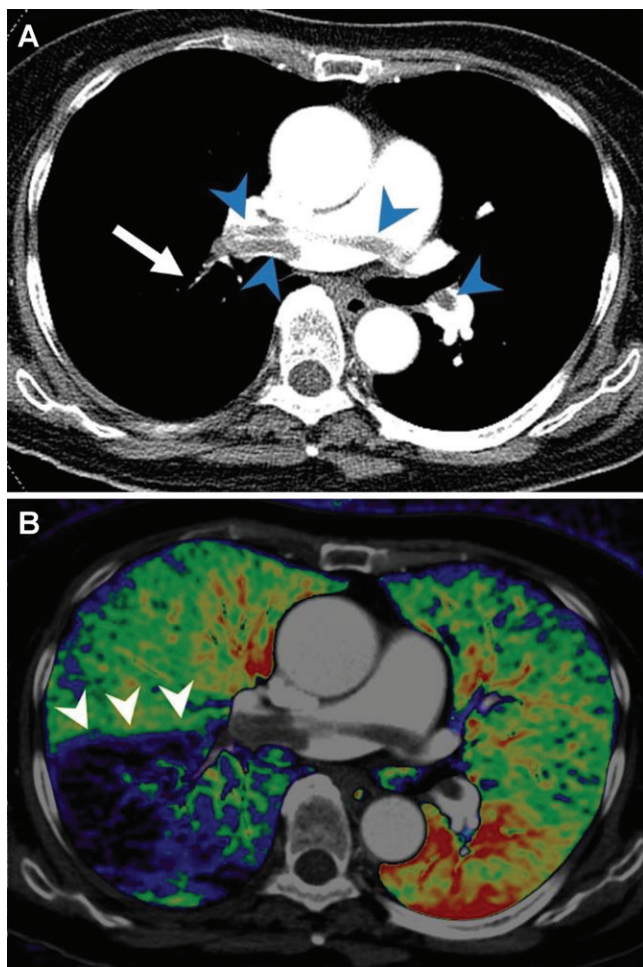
Example of dual-energy CT angiography in a patient with acute pulmonary embolism. A, Axial CT pulmonary arteriographic image shows saddle emboli in the main pulmonary artery and right and left pulmonary arteries (arrowheads) and small clots in a segmental pulmonary artery in the right lower lobe (arrow). B, Axial fusion image of pulmonary blood volume map of dual-energy CT shows large wedge-shaped perfusion defects in the right lower lobe (arrowheads).
